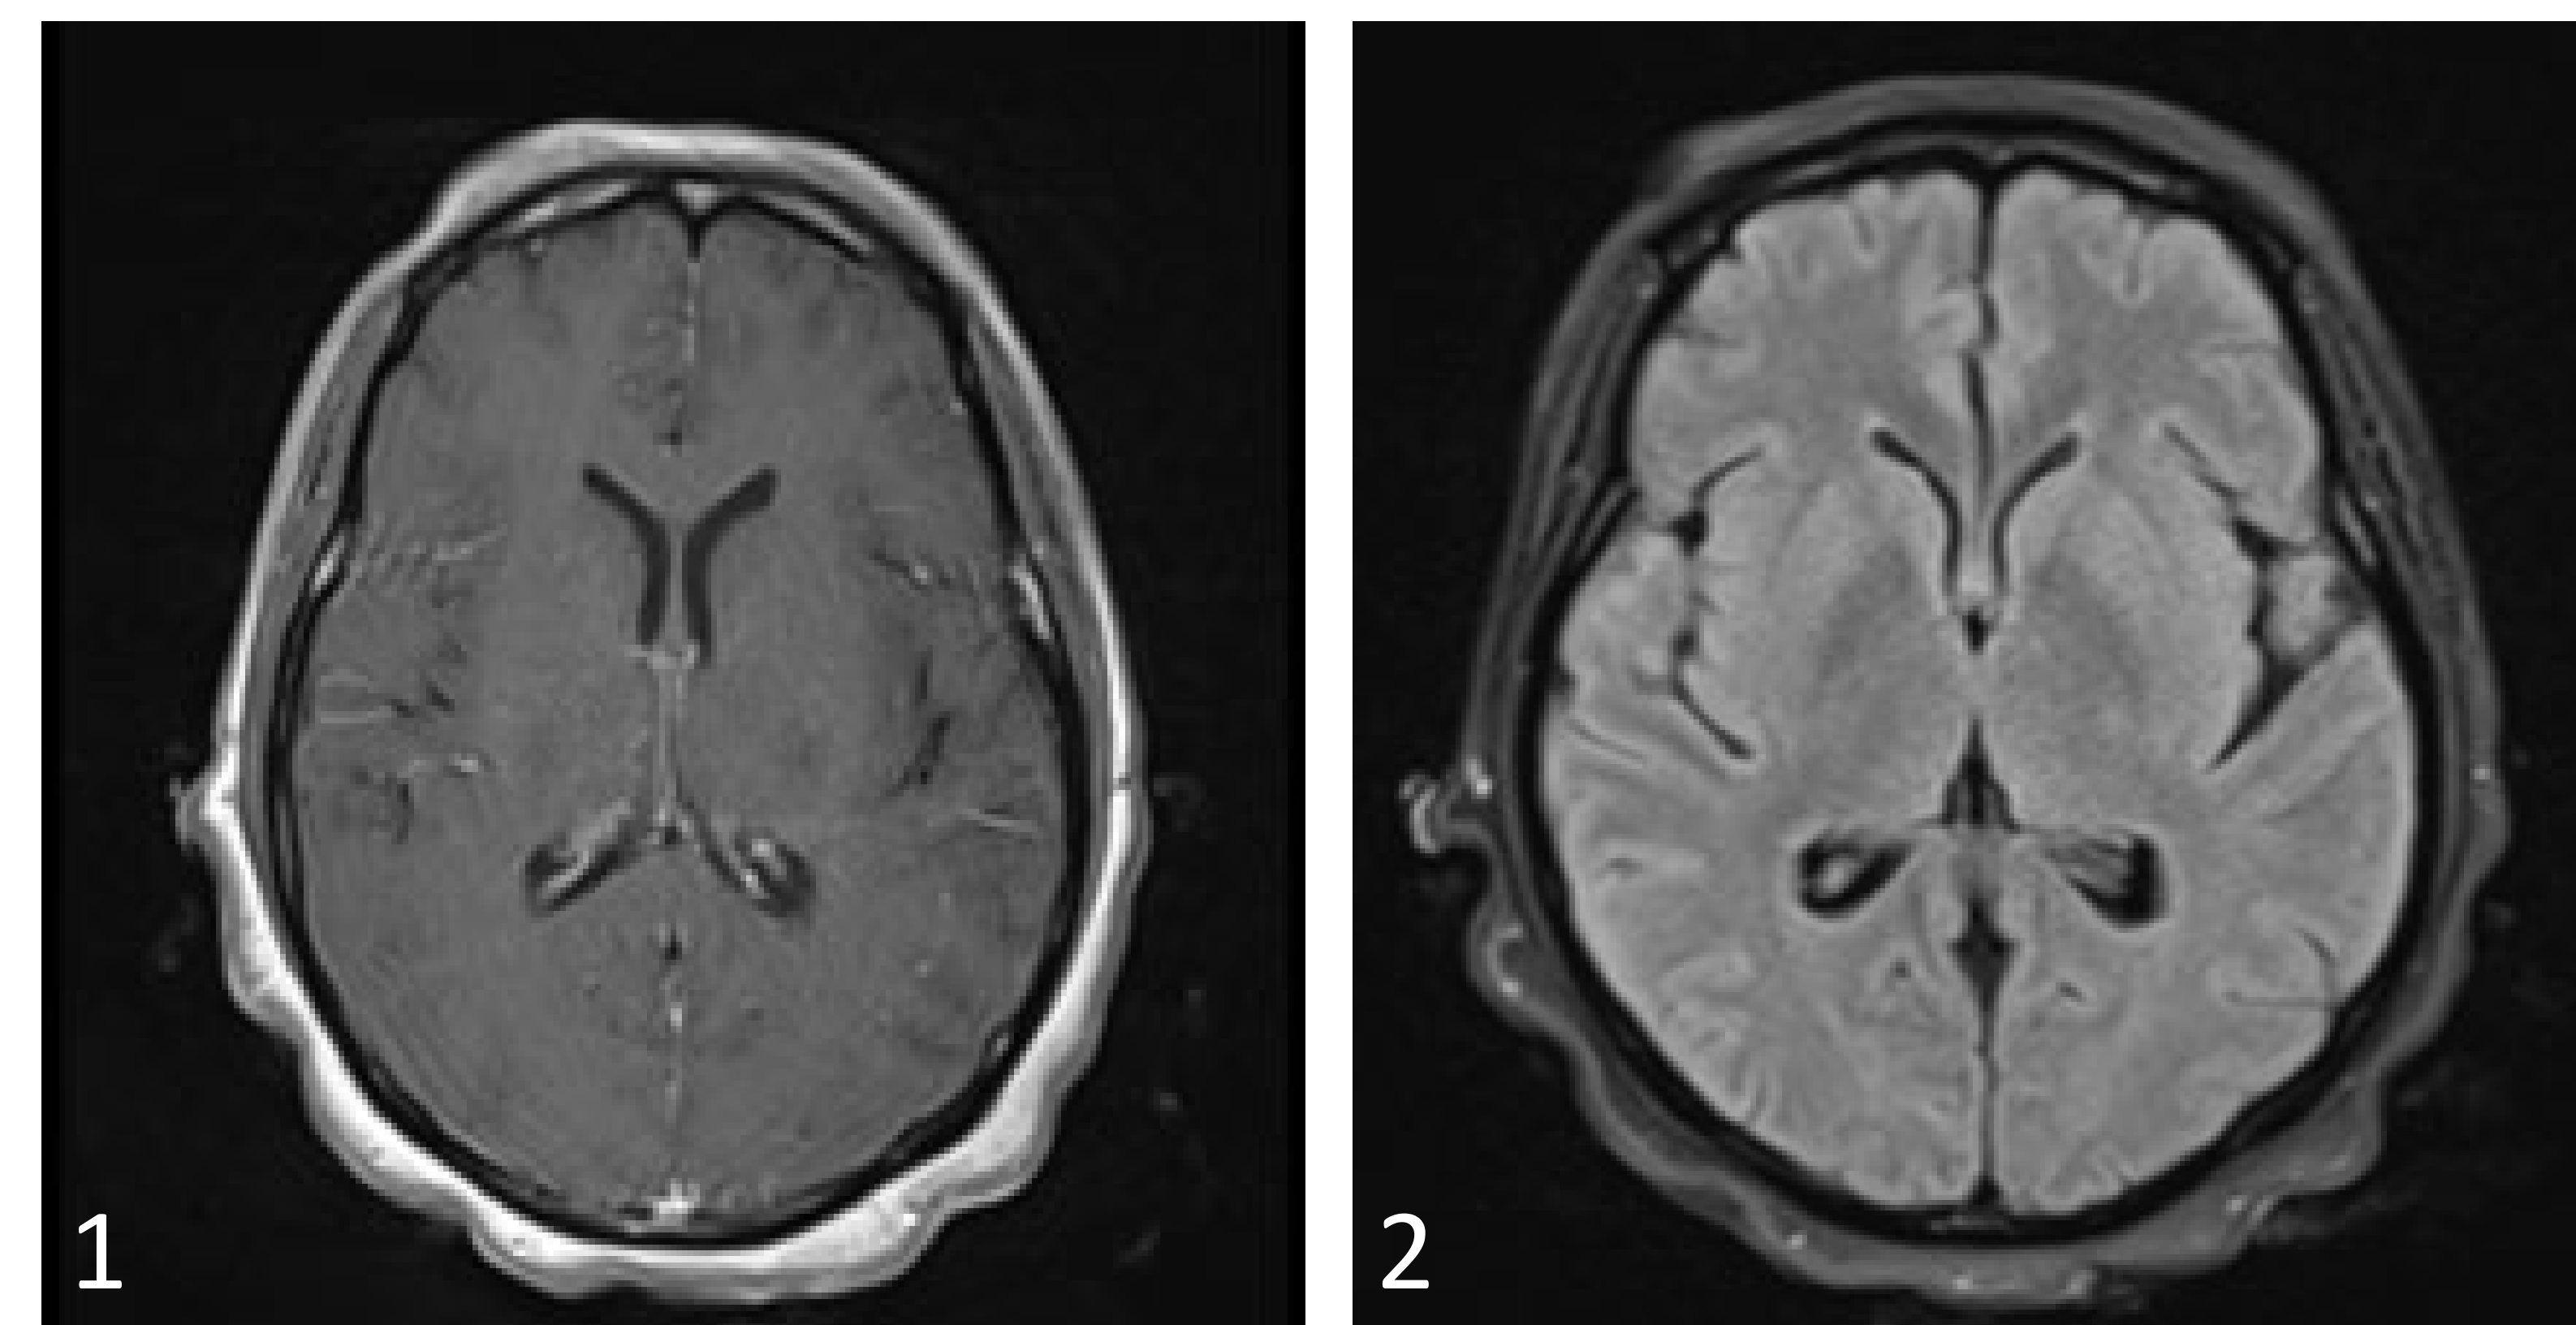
Post-contrast MRI imaging did not reveal meningeal irritation to suggest underlying infection.
